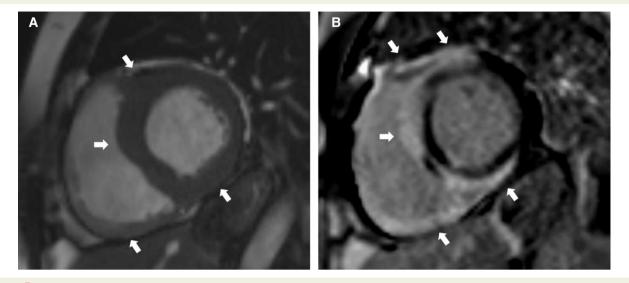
Magnetic resonance images of a patient with right bundle branch block, ventricular tachycardia, and depressed left and right ventricular function; cardiac sarcoidosis was verified by endomyocardial biopsy. The arrows point at key findings. (A) Short-axis cardiac cine image showing thickened left ventricular myocardium and inferior right ventricular wall. (B) A 'hook sign' pattern of cardiac sarcoidosis⁷⁶ characterized by late gadolinium enhancement in the septum continuing to ventricular insertion points and right ventricular free wall.
